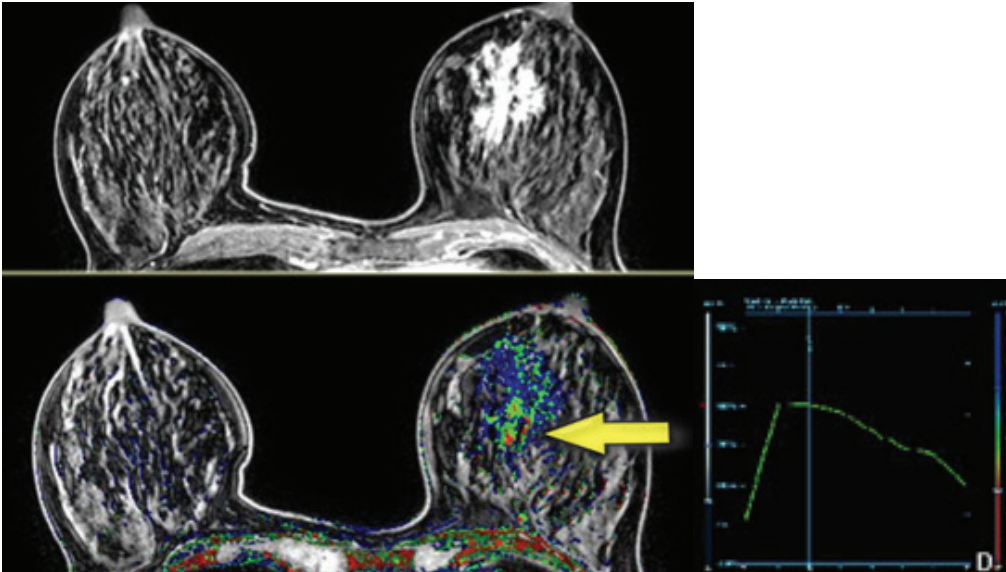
Contrast enhanced breast MRI
